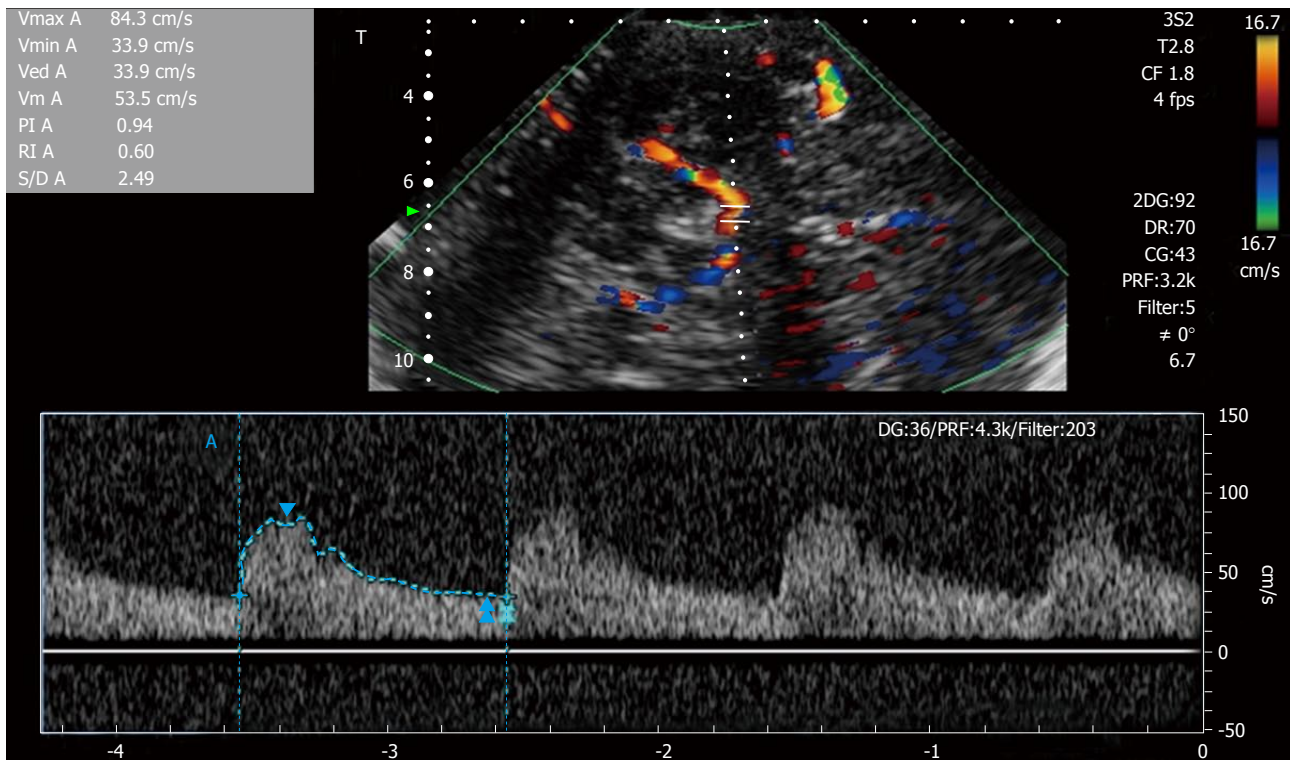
Transcranial Doppler spectral Doppler study of intracranial middle cerebral artery.
